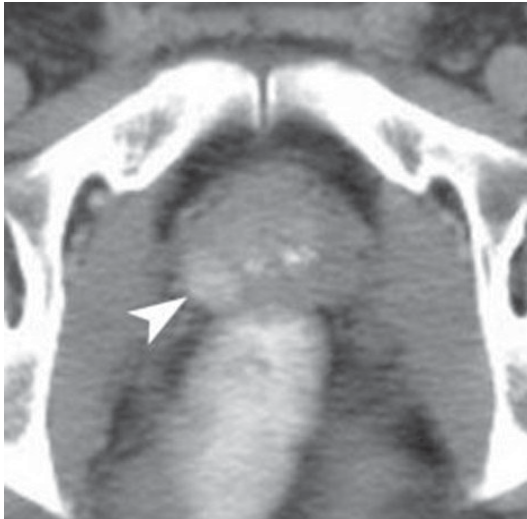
Computed tomography. Prostatic carcinoma. Incidental finding of a lesion (*arrowhead*) in the left lobe. The nodule appears hyperattenuating after contrast medium injection
